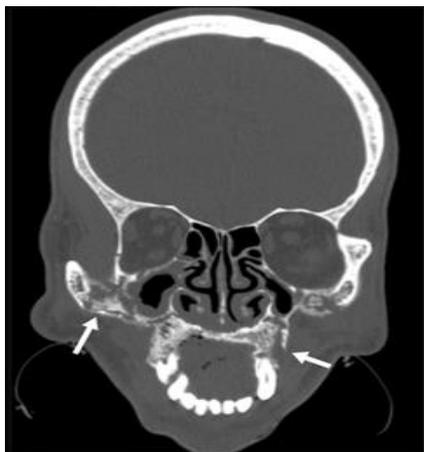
Non-contrast CT scan coronal image shows osseous erosions and sclerosis involving the hard palate and bilateral zygomatic bones giving a mottled appearance. Mild soft tissue thickening is noted in the right maxillary sinus with partial occlusion of maxillary ostium.
